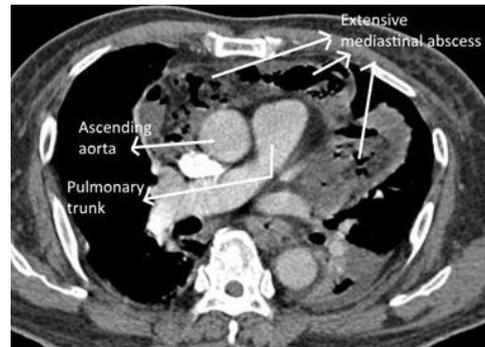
Annotated CT axial view of thorax revealed extensive superior and anterior mediastinal abscess.
